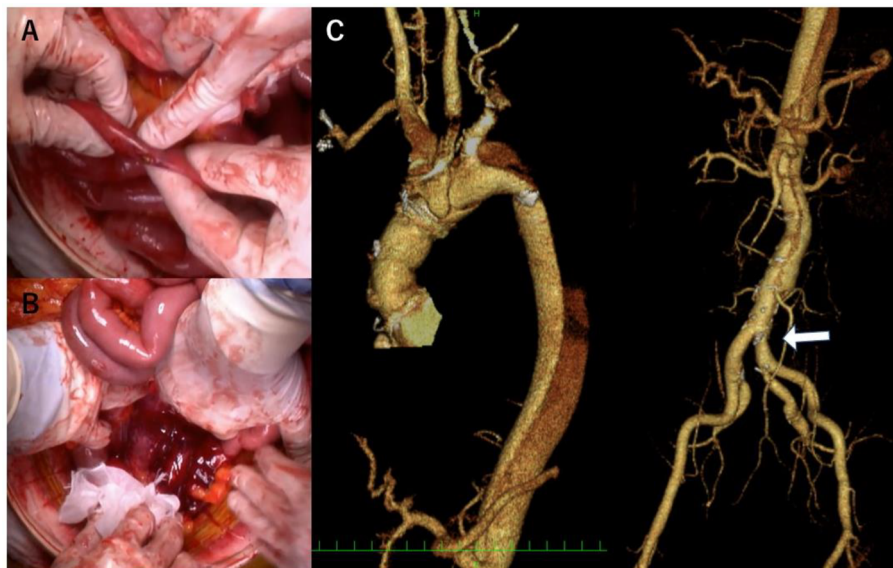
Intraoperative findings and postoperative computed tomography (CT). (A) The ileum's intestinal perforation. (B) Retroperitoneal bleeding in Zones I and II. (C) The left common iliac artery's (↓) postoperative CT showed improved malperfusion.
